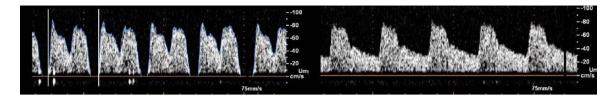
Measurement of transcranial Doppler (TCD) flow velocity of the middle cerebral artery (MCA) with and without the intra-aortic balloon pump (IABP).
